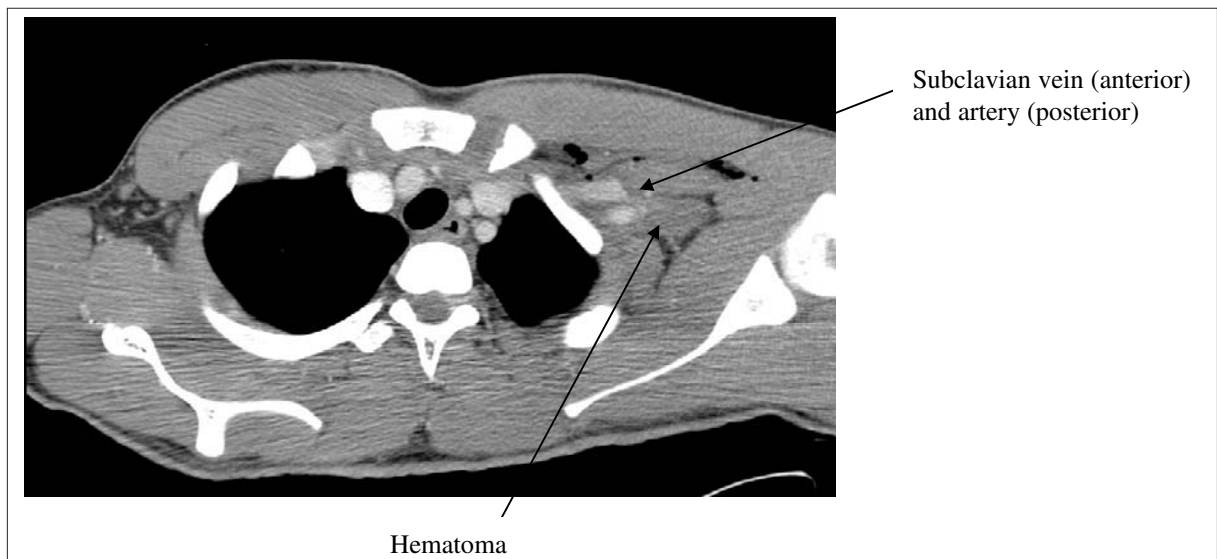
CT of the chest demonstrating extrapleural hematoma adjacent to the subclavian artery.
